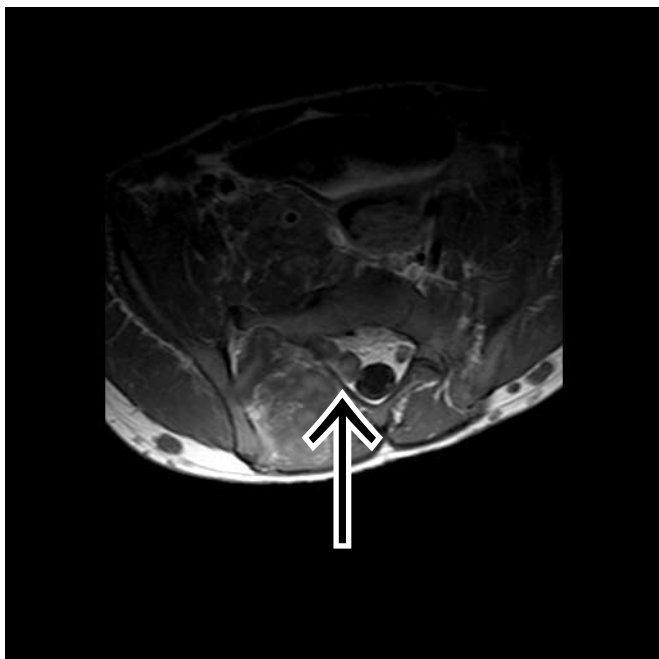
Axial T1-weighted MRI of the lumbar spine showing exiting neurofibroma along the nerve root at the level of the sacral nerve (courtesy of Dr Z Ebrahim).
